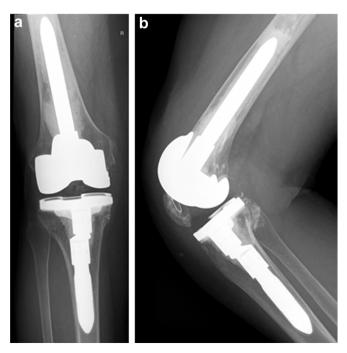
AP (a) and lateral (b) radiograph 3 mo after revision surgery.
